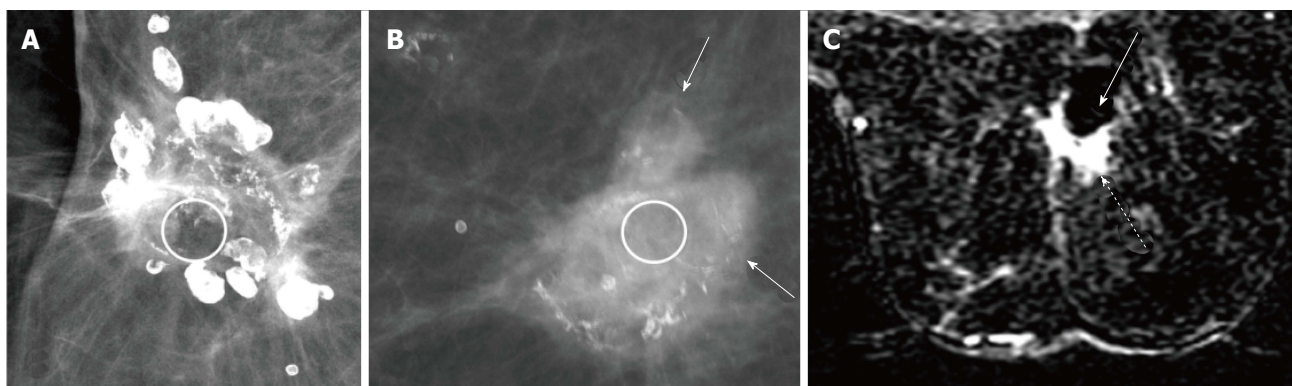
In dystrophic or benign calcifications, fat lucency (circle) is present within as seen in (A) while in calcifications associated with recurrence (arrows), the centre appears dense (circle) as shown in (B), (C) subtracted post contrast MRI image of the patient in (B) shows a seroma cavity (solid arrow) with an enhancing solid component (dashed arrow) in the periphery anteriorly.
